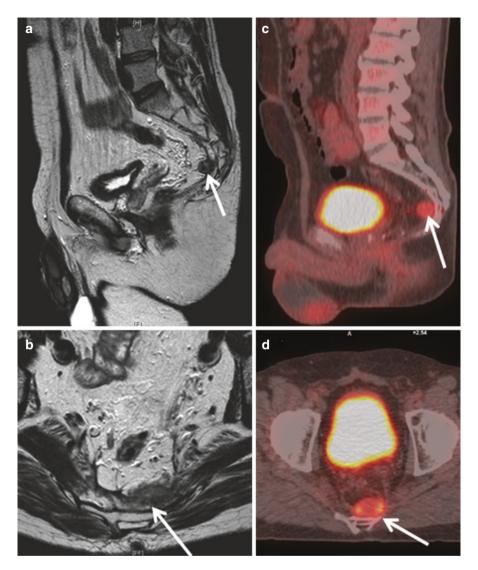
Role of FDG PET-CT in recurrent colorectal cancer. 57-year-old male with previous low anterior resection and clinical suspicion of local recurrence. MR imaging on T2 W sagittal (a) and axial (b) planes demonstrate a suspicious intermediate signal rounded lesion in the presacral soft tissues. Fused FDG PET-CT images in corresponding plane demonstrate very high intensity focal eccentric uptake (arrows in c and d) in this soft tissue lesion consistent with recurrent disease. FDG PET-CT has high accuracy in characterization of indeterminate presacral masses
